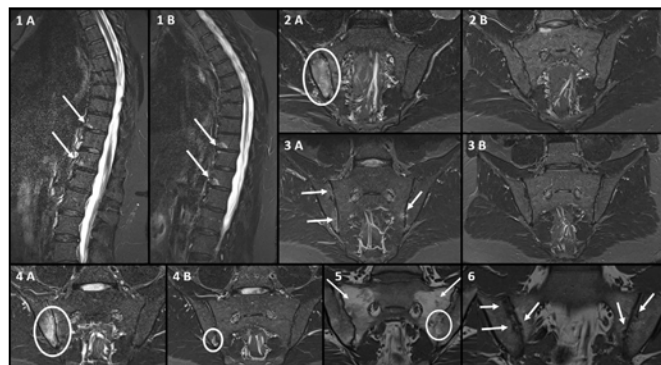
Examples of axial involvement on MRI in early peripheral spondyloarthritis. (1A) Baseline STIR images of a 52-year-old woman displaying spinal bone marrow oedema (corner lesions; indicated by arrows); (1B) STIR images at timepoint of sustained clinical remission of the peripheral manifestations: no decrease on treatment with golimumab (corner lesions indicated by arrows). (2A) Severe iliac bone marrow oedema (indicated by circle) on baseline STIR images in a 28-year-old man; (2B) complete resolution of bone marrow oedema at sustained clinical remission of peripheral spondyloarthritis. (3A) Bilateral sacroiliac bone marrow oedema (indicated by arrows) on STIR images at baseline in a 37-year-old man; (3B) complete resolution of the sacroiliac bone marrow oedema at sustained clinical remission of peripheral spondyloarthritis. (4A) Severe sacroiliac joint bone marrow oedema (indicated by circle) on baseline STIR images in a 29-year-old man; (4B) residual bone marrow oedema (indicated by circle) on remission MRI. (5) Extensive fat metaplasia (indicated by arrows) and partial ankylosis (indicated by circle) on baseline T1 images in a 39-year-old man. (6) Bilateral sacroiliac joint erosions (indicated by arrows) on baseline T1 images in a 37-year-old man. STIR, short tau inversion recovery.
